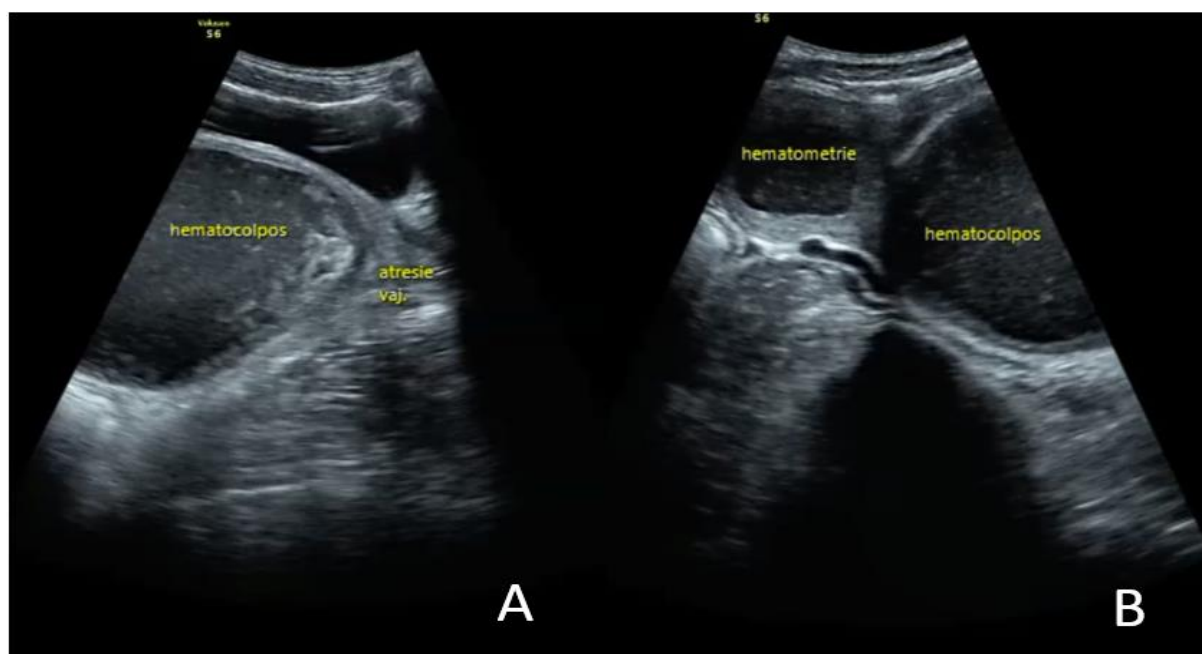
Ultrasound images showing A: reports of vaginal atresia with the bladder in front, the rectum behind and the hematocoplos above, B: repercussions on the upper apparatus with hematometry image.
